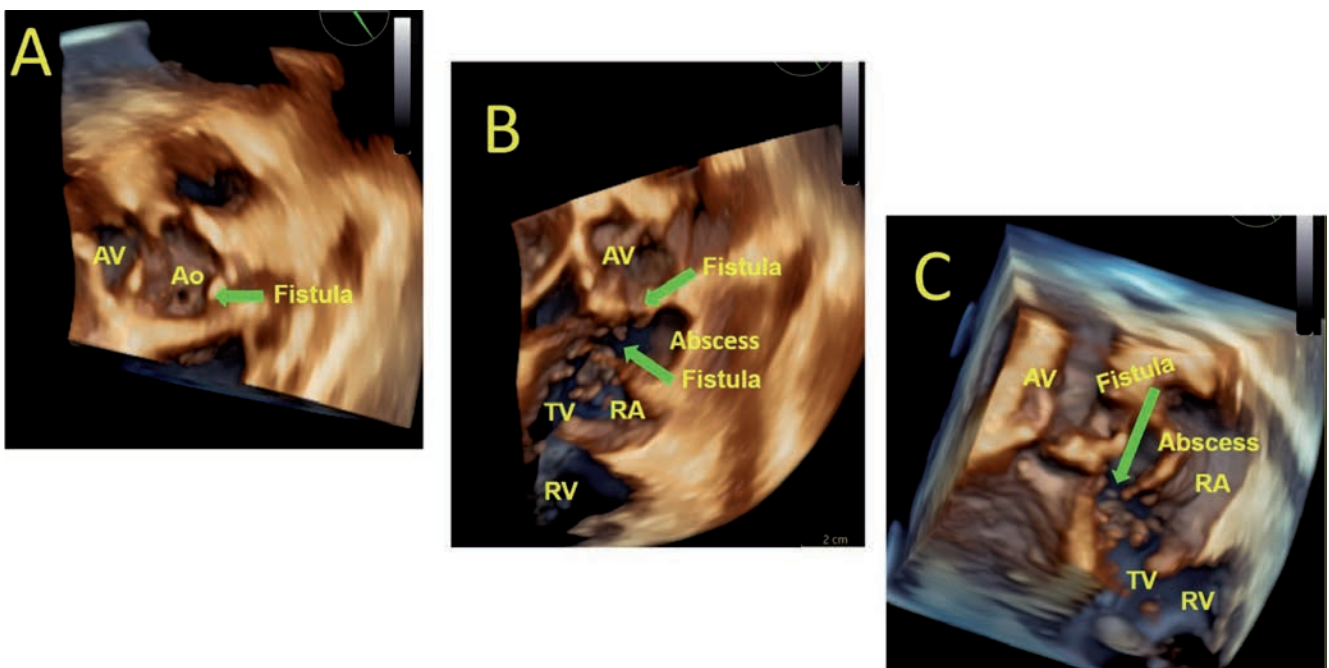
Transesophageal echocardiogram 3D reconstruction. A) Non-coronary sinus with the fistula; B) aortic root and right chamber; C) aortic root and right chambers with abscess and fistula. AV, aortic valve; Ao, aorta; RA, right atrium; RV, right ventricle; TV, tricuspid valve.
